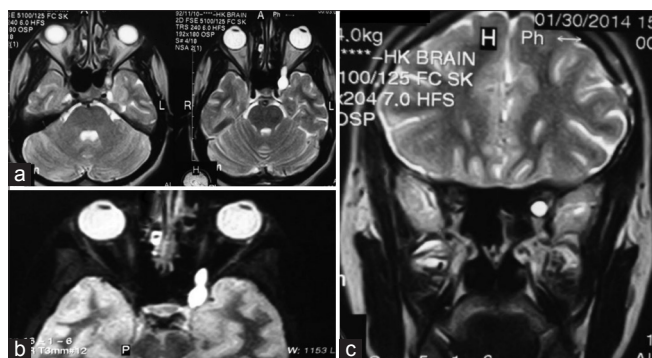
T2 weighted MRI of the orbit; (a and b) axial views, (c) coronal view.
